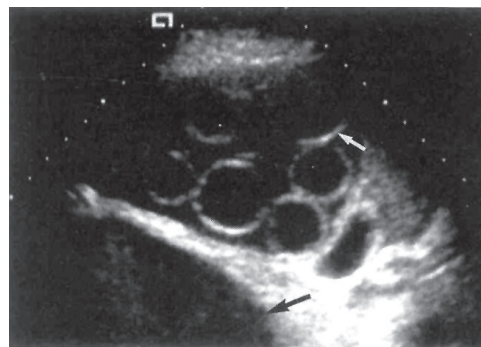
Ultrasound: Hydatid cyst with daughter cysts
